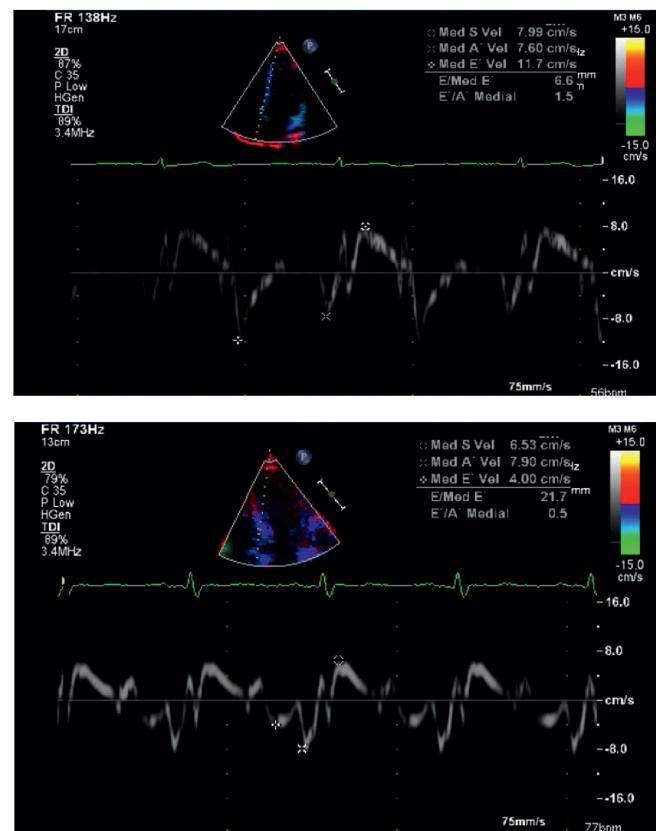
Exemplar tissue-Doppler images taken at the septal wall in an athlete (a), note the positive E'/A' ratio of 1.5 and the E/E' ratio of 6.6, and a patient with hypertrophic cardiomyopathy (b), note the reversed E'/A' ratio of 0.5 and the elevated E/E' of 21.7.
